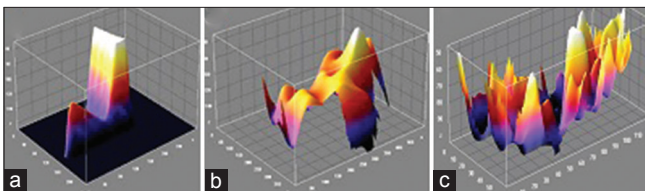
Representative three-dimensional outlines of hippocampal areas done on magnetic resonance imaging brain of the subjects and patients from the current study (Pseudoimages generated by ImageJ, National Institute of Health, USA, downloaded free by <http://www.imagej.nih.gov/ij>. (a-c) have been drawn to show comparison of normal hippocampus (a) in healthy individuals with those with Alzheimer's disease (b). (c) Represents the manually drawn outlines of right medial temporal lobe for comparison
